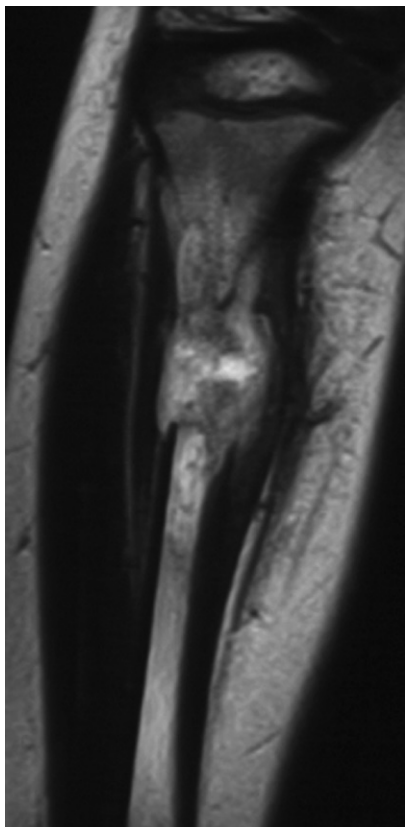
Osteomyelitis. T2-weighted MRI scan showing a high signal in the medulla of the tibia extending into the cortex and soft tissues. Same patient as Fig. 11.19d.
